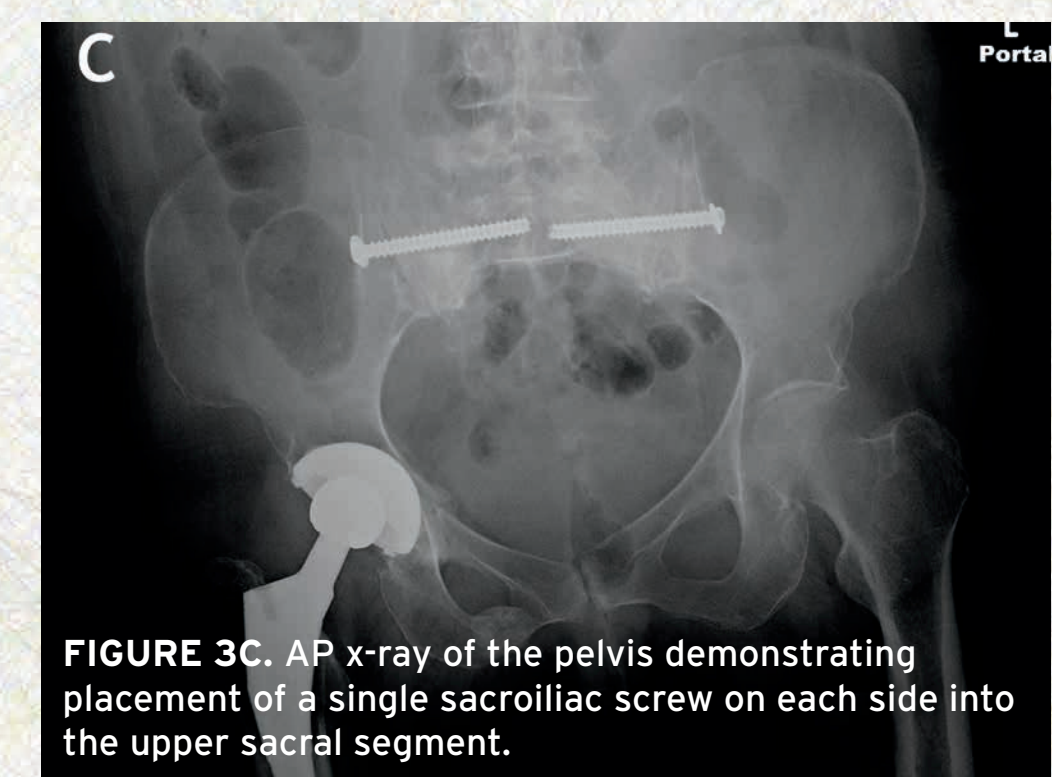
AP x-ray of the pelvis demonstrating placement of a single sacroiliac screw on each side into the upper sacral segment.
